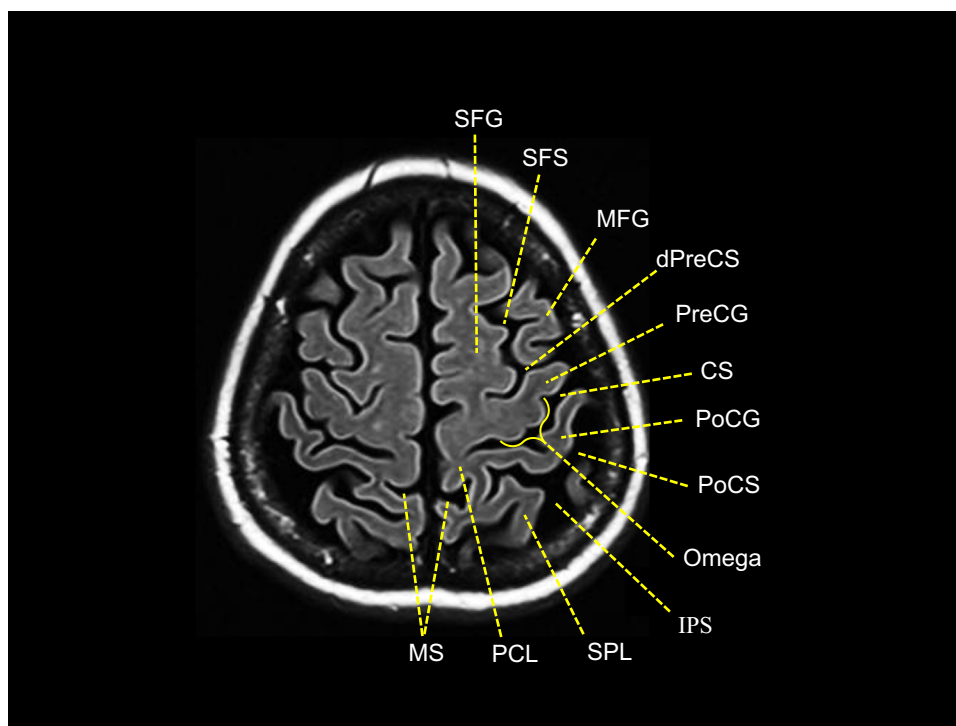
Axial FLAIR image showing landmarks helpful in identifying the central sulcus and sensorimotor anatomy. CS, central sulcus; dPreCS, dorsal precentral sulcus; FLAIR, fluid-attenuated inversion recovery; IPS, intraparietal sulcus; MFG, middle frontal gyrus; MS, marginal sulcus; PCL, paracentral lobule; PoCG, postcentral gyrus; PoCS, postcentral sulcus; PreCG, precentral gyrus; SFG, superior frontal gyrus; SFS, superior frontal sulcus; SPL, superior parietal lobule; Omega: omega shaped along the posterior bank of the precentral gyrus approximates the distal upper extremity MI. (Color version of figure is available online.)
